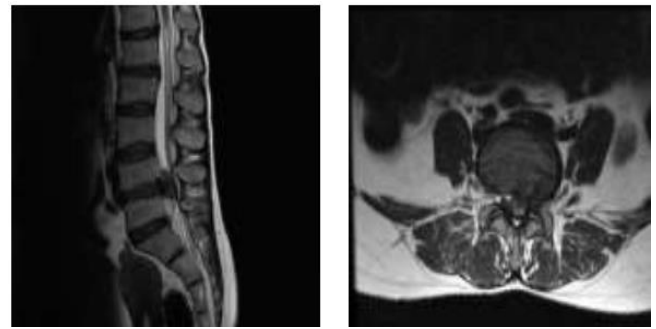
Pre op MRI T2 Sagittal and axial images showing large paracentral disc at L4 L5 level.
